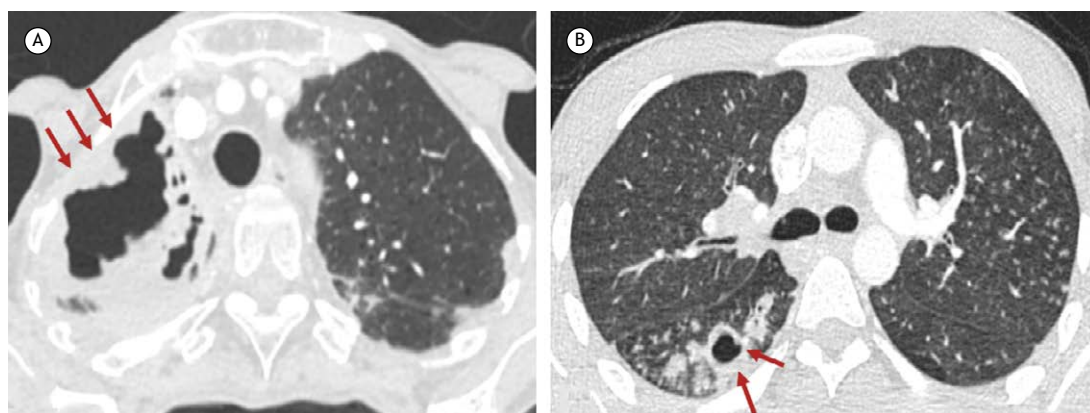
Axial CT scans with lung window settings. In A, a large fungal cavity occupying the right upper lobe (arrows). In B, a small cavity in the upper segment of the right lower lobe with several surrounding centrilobular nodules in a patient with pulmonary tuberculosis (arrows).
